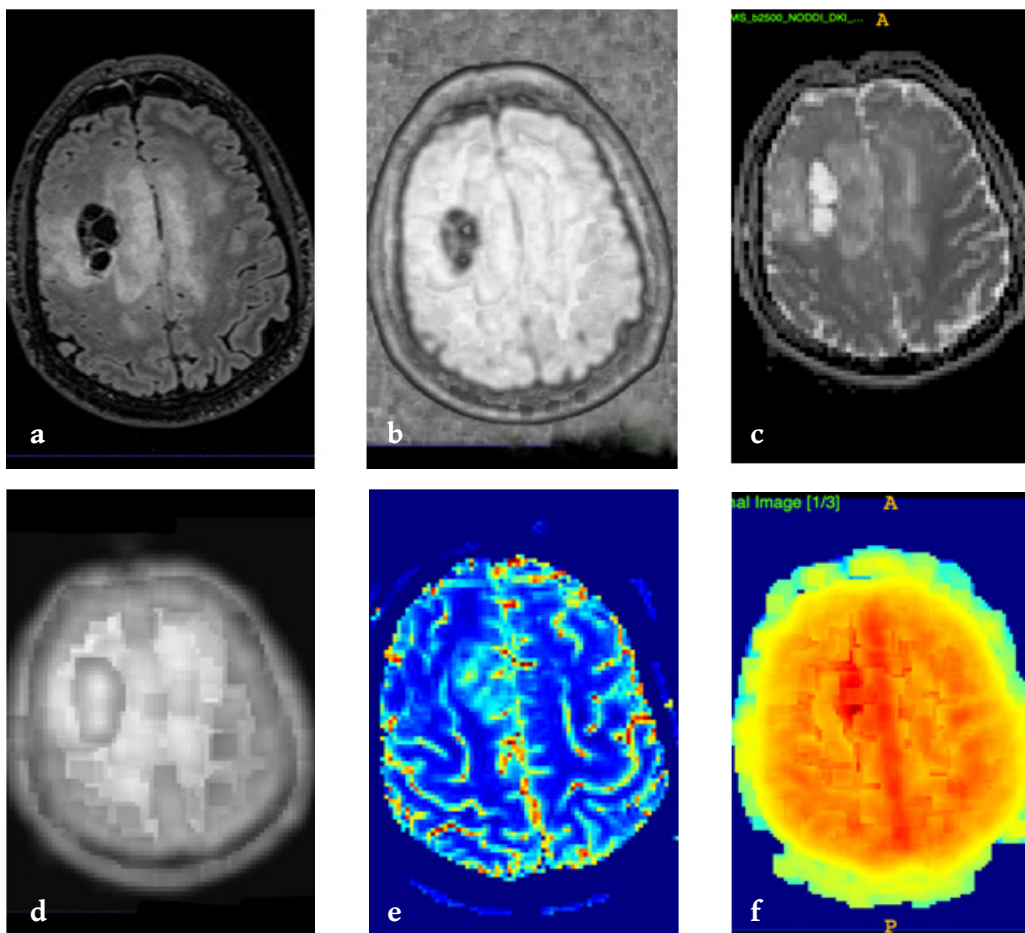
T2-FLAIR (a) and textural features (b) images of an IDH-mutant, MGMT-methylated right temporal GBM.
